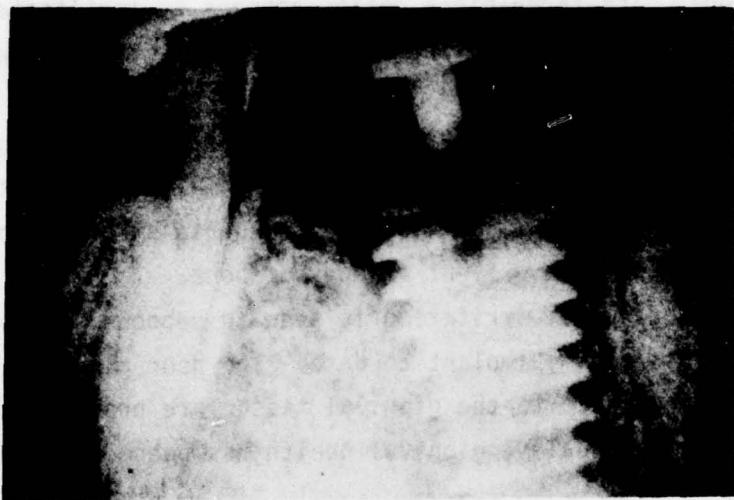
RADIOGRAPH OF HUMAN IMPLANT IN PLACE FOR TWO MONTHS
